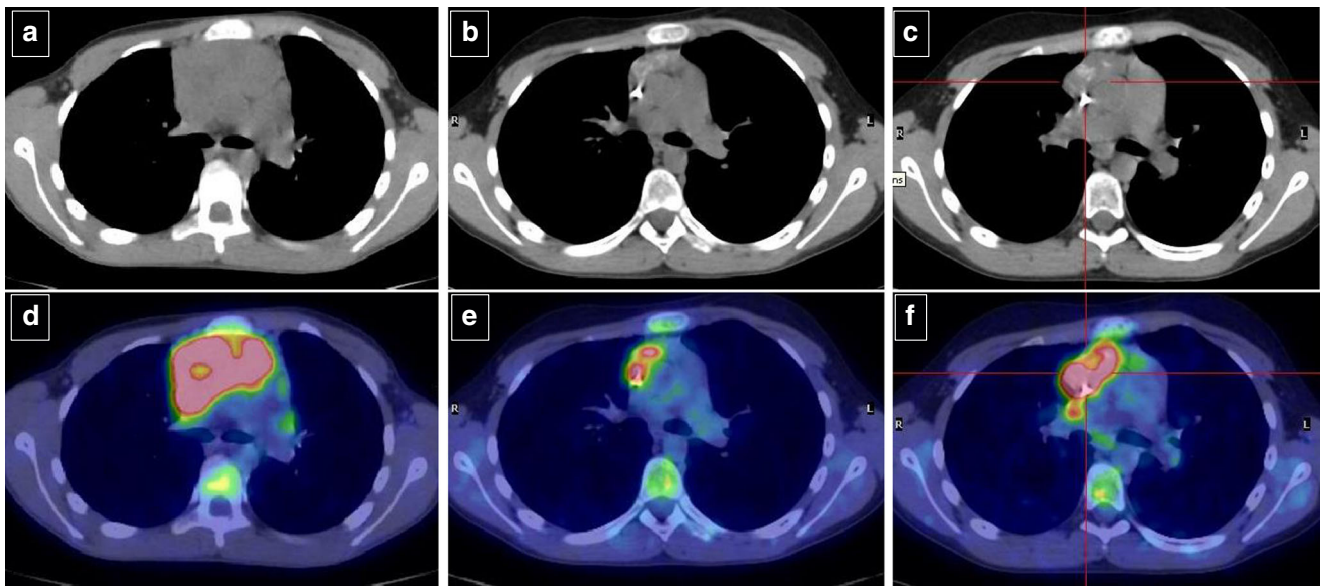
PET imaging in a patient with a mediastinal bulk at baseline (a, d), after four cycles of chemotherapy (b, e) and after the end of treatment (c, f). Axial low-dose CT images (a–c) and corresponding axial fused PET/
